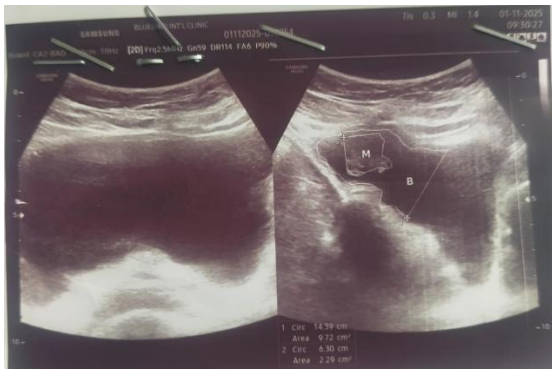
Transabdominal ultrasound showing a well-defined heterogeneous hypoechoic mass involving the anterior bladder wall, suggestive of deep infiltrating bladder endometriosis
